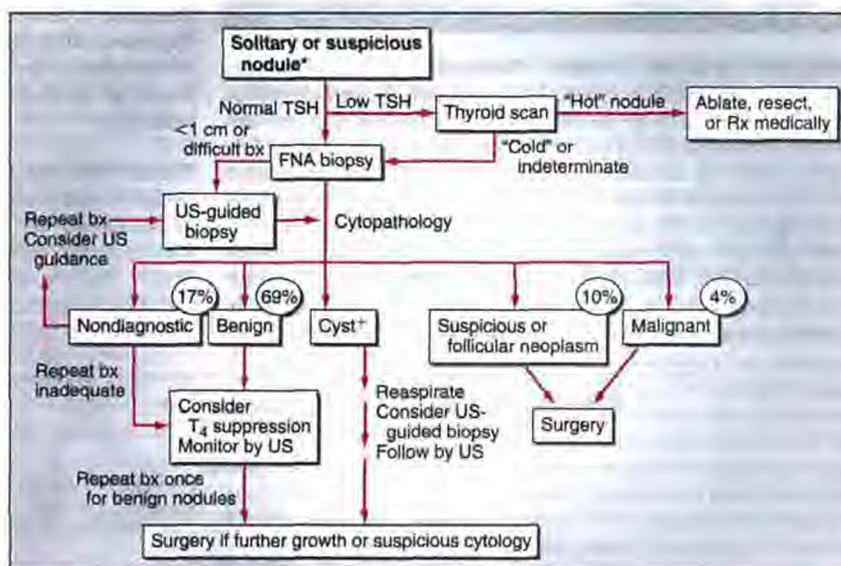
Approach to the patient with a thyroid nodule. \*There are many exceptions to the suggested options. See text and references for details. †About one-third of nodules are cystic or mixed solid-cystic. US, ultrasound; TSH, thyroid-stimulating hormone; FNA, fine-needle aspiration.
